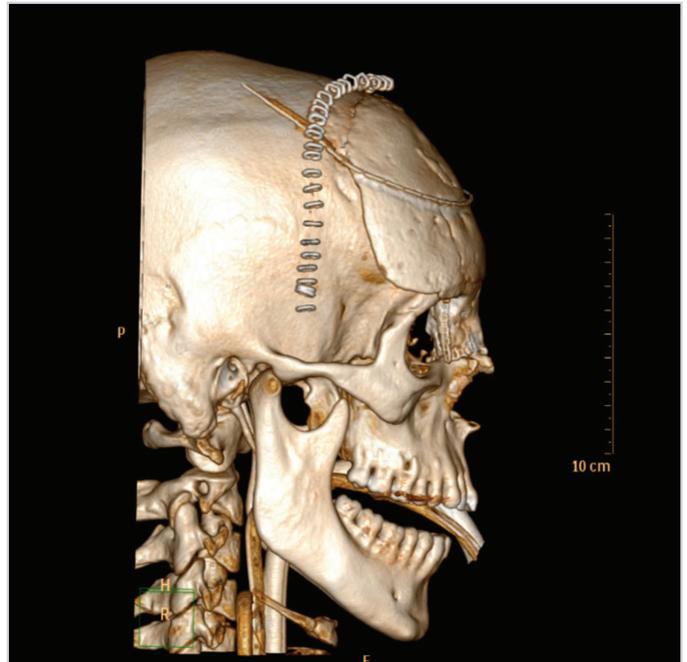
Lateral view of CT scan with 3D reconstruction showing a complete removal of the mass
